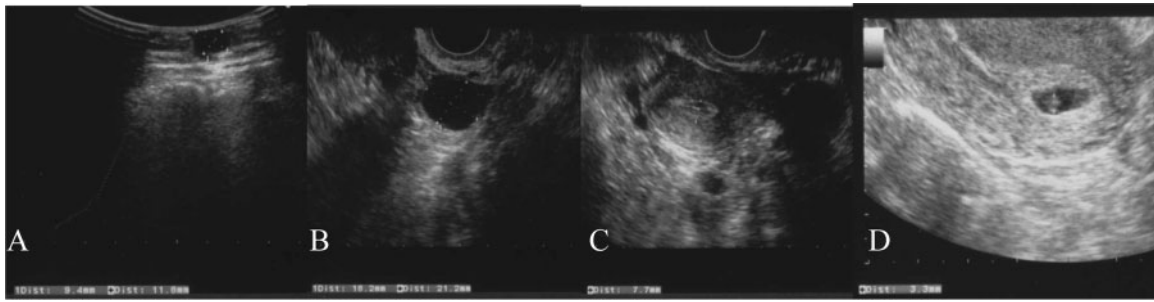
Ultrasound observed at day 11 (LH peak) of the last cycle: subcutaneous follicle (A), ovarian follicle (B) and endometrium (C). Confirmation of an intrauterine pregnancy at day 30 of the luteal phase (D).
